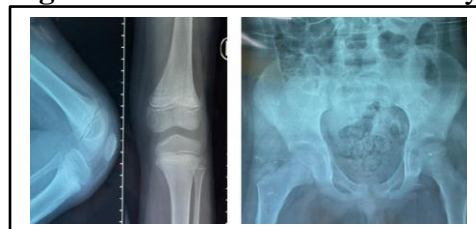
Xray of left knee showing scurvy features. Normal pelvis xray.
